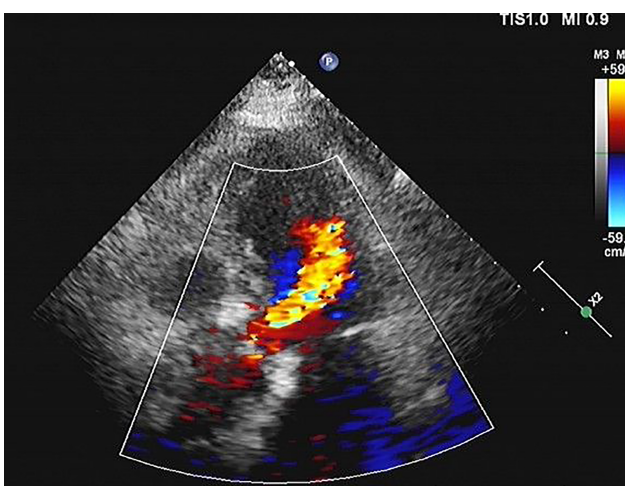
The post-surgery echocardiography showed slight mitral regurgitation.
